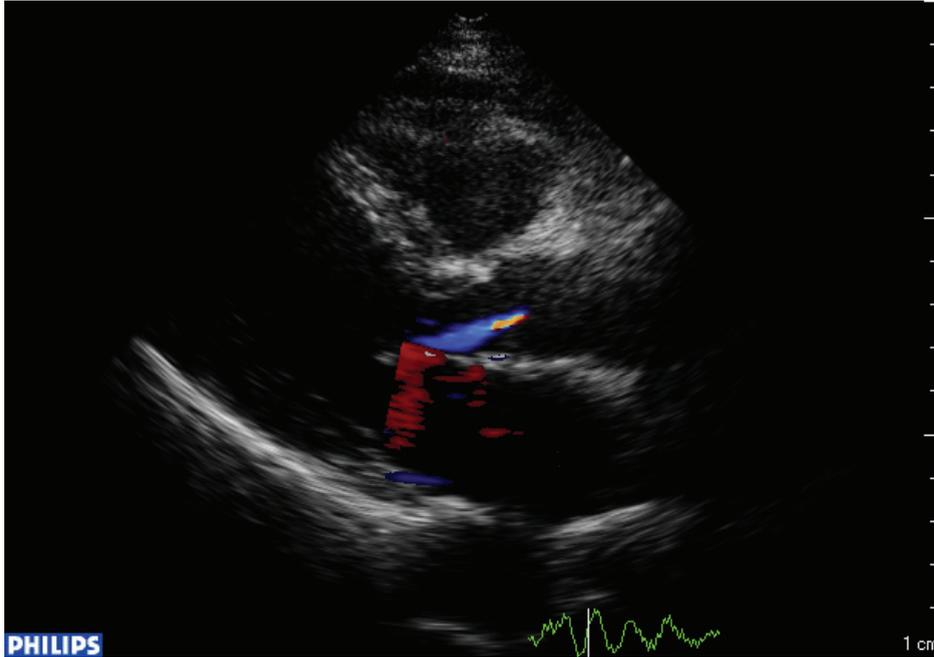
Echocardiogram of RA patient BS female, age 50 - aortic valve insufficiency
